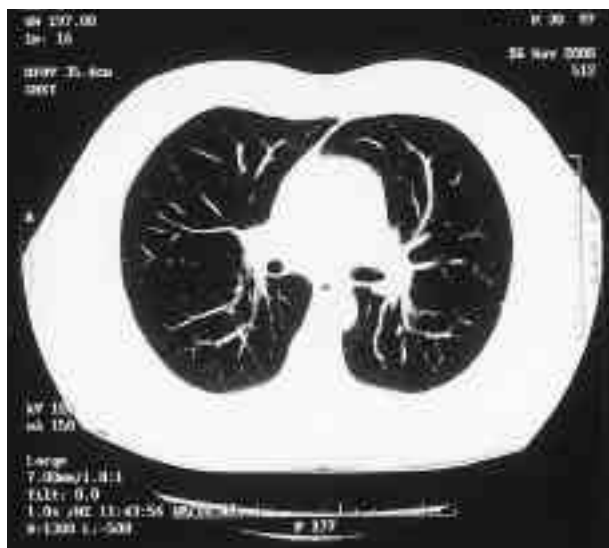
CT scan 18 months after surgery showing no evidence of recurrence
